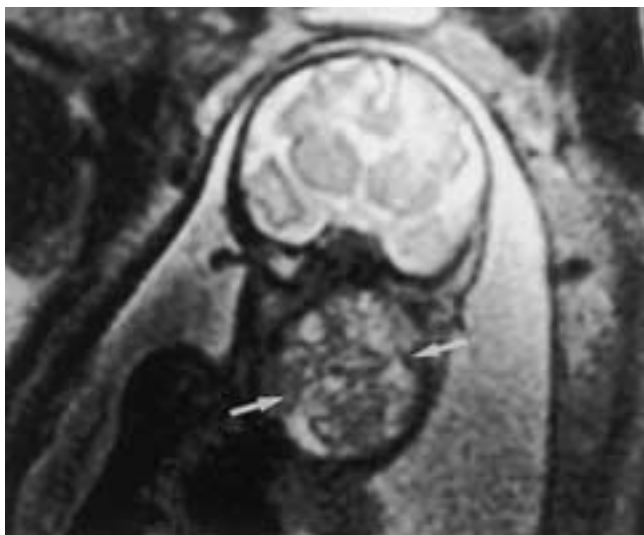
Fetal teratoma. Coronal single-shot FSE T2-weighted MR image reveals a heterogeneous neck mass (arrows) that is obstructing the trachea. Elective cesarean section was subsequently performed, the baby's airway was secured, and the teratoma was successfully resected.
